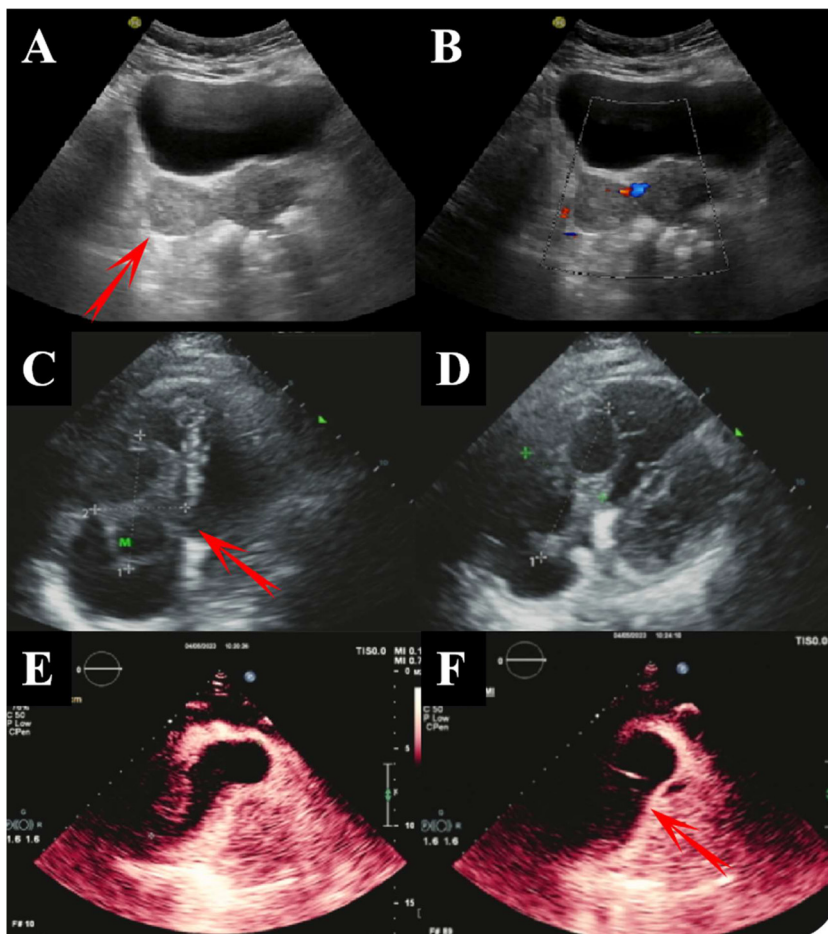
(A, B) Transabdominal gynecologic ultrasound revealed a right parametrial isoechoic mass. (C, D) Cardiac ultrasonography of the right atrioventricular junction showed a solid hypoechoic mass that measured 71 × 32 mm. (E, F) After injection of acoustic contrast, a negative filling defect area was seen in the right heart cavity, measuring about 84 × 34 mm, and a small amount of contrast agent was seen in the lesion.
